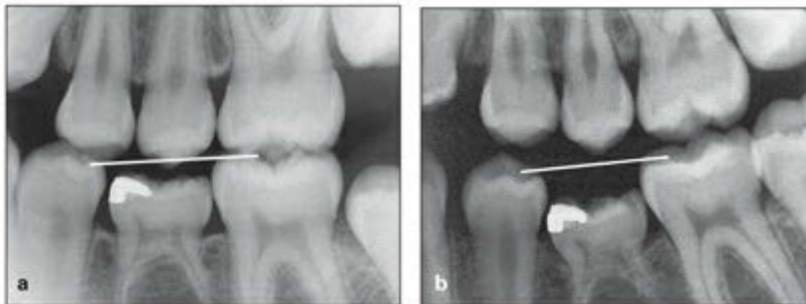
(*a and b*) Periapical radiographs showing the increasing submergence of the primary molar over 16 months.
